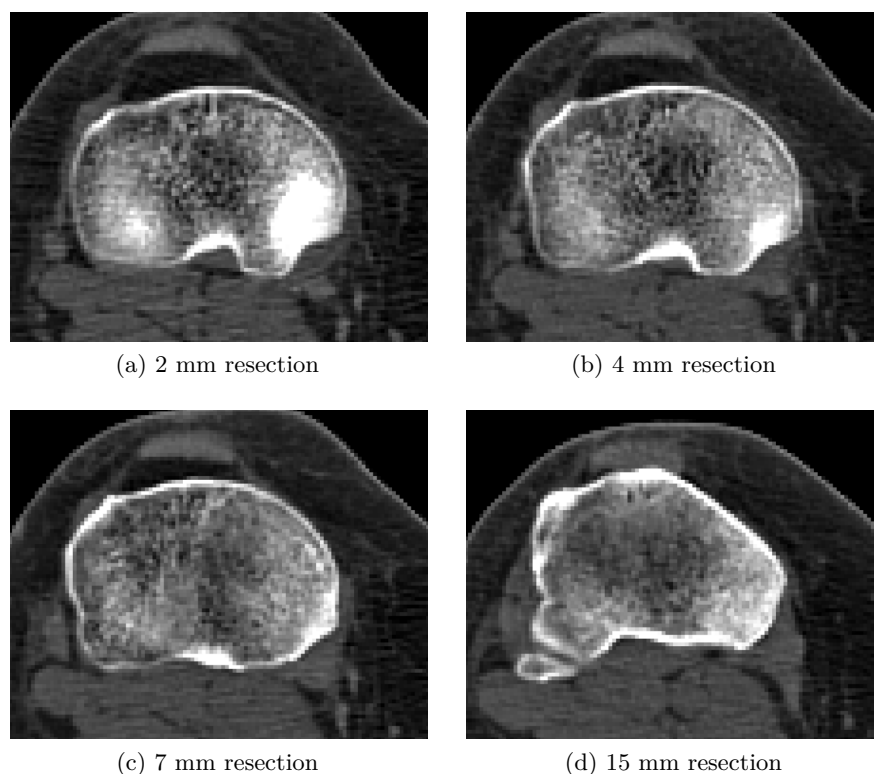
Slices from a CT scan of the left tibia at different resection levels. The cortical shell thickens at deeper resections. Orientation of the scans is such that left is lateral, and top is anterior.
